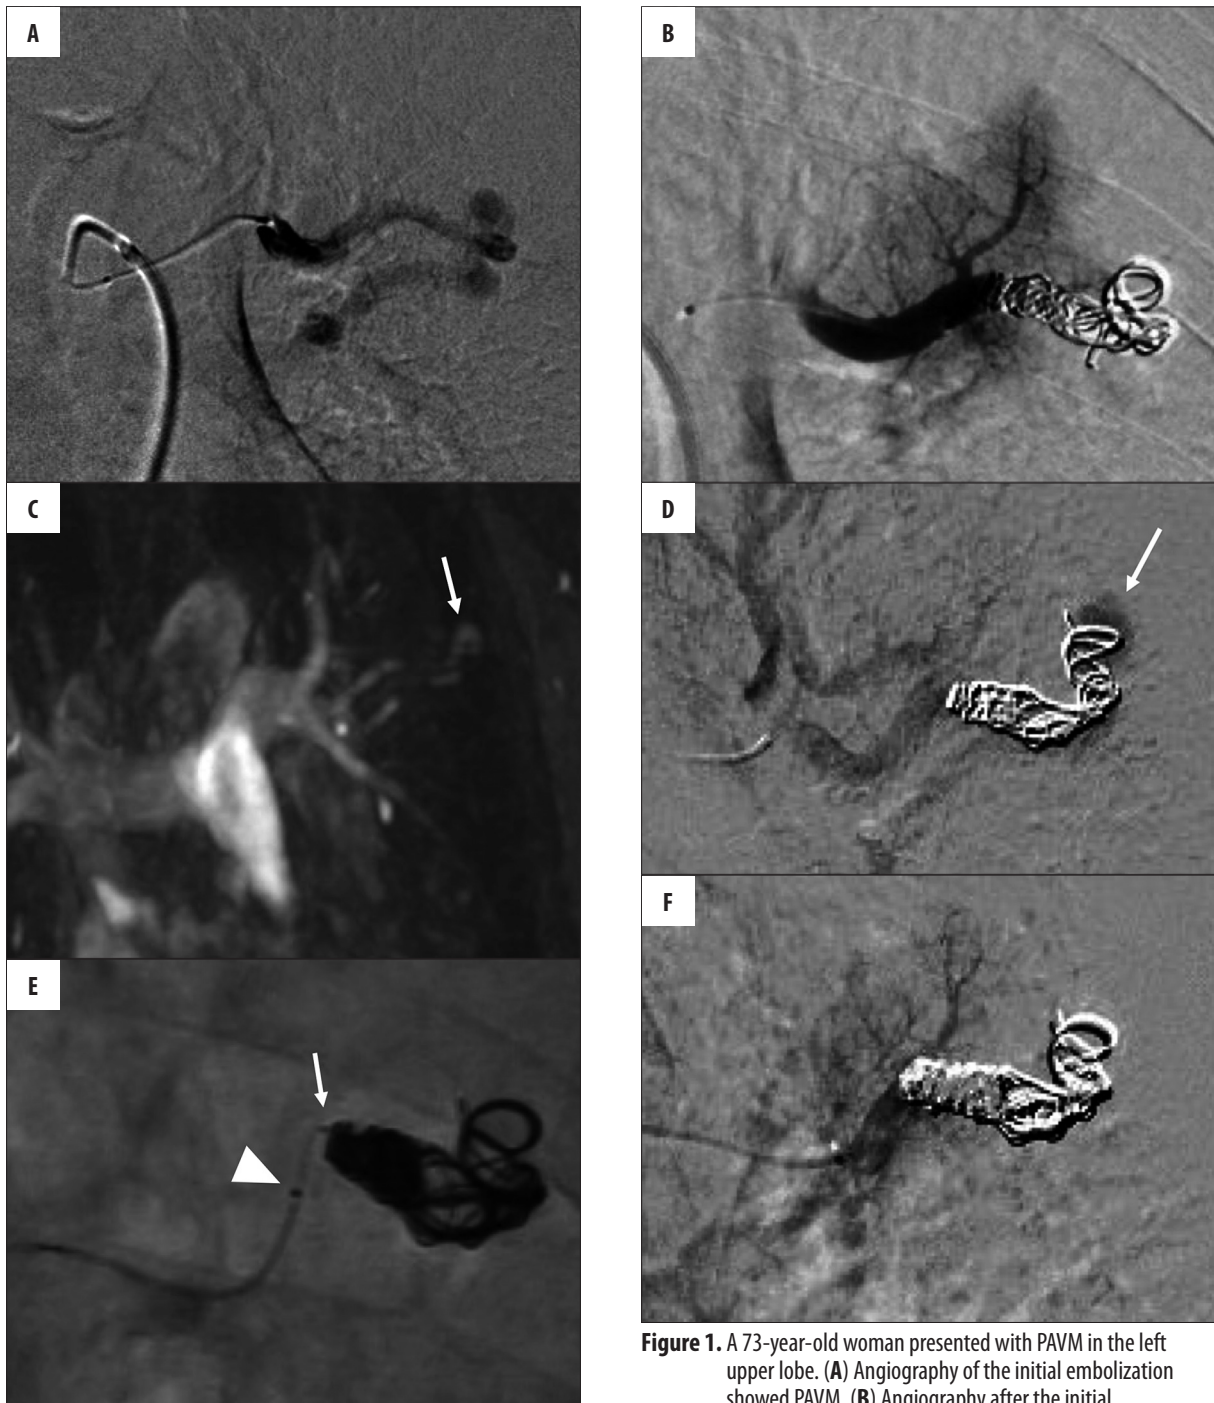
A 73-year-old woman presented with PAVM in the left upper lobe. (A) Angiography of the initial embolization showed PAVM. (B) Angiography after the initial embolization revealed that PAVM was completely embolized using coils. (C) Contrast-enhanced MRI performed 42 months after the initial coil embolization showed recanalization (arrow). (D) Angiography before re-embolization showed recanalization. (E) Coil embolization was performed using the triaxial system. The 1.9-Fr. no-taper microcatheter (arrow) could be inserted into the original coils with good support from the 2.7-Fr. microcatheter (arrow head). (F) Angiography after re-embolization showed a complete cessation of blood flow. The normal branch of the pulmonary artery was saved.
